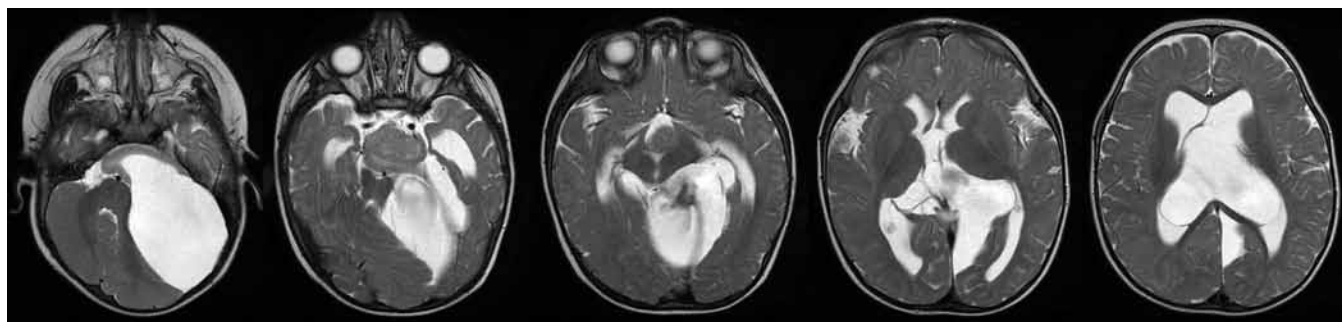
Axial T2-weighted MR images depicting the large cystic tumor component with space-occupying effect and compression of the left cerebellar hemisphere and dislocation of the brainstem. Also apparent is mild hydrocephalus with widening of the lateral ventricles and the third ventricle.
